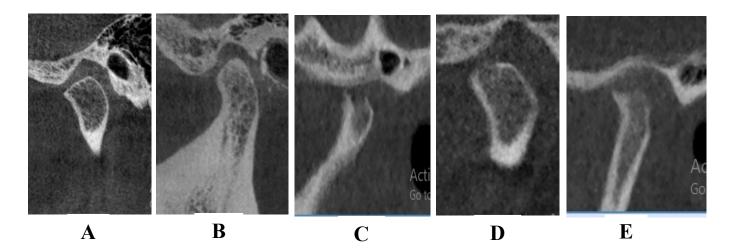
Oblique sagittal view of CBCT of TMJ osteoarthritic changes; A- Flattening, B- Subcortical sclerosis, C- Resorption, D- Erosion, E- Osteophyte.
